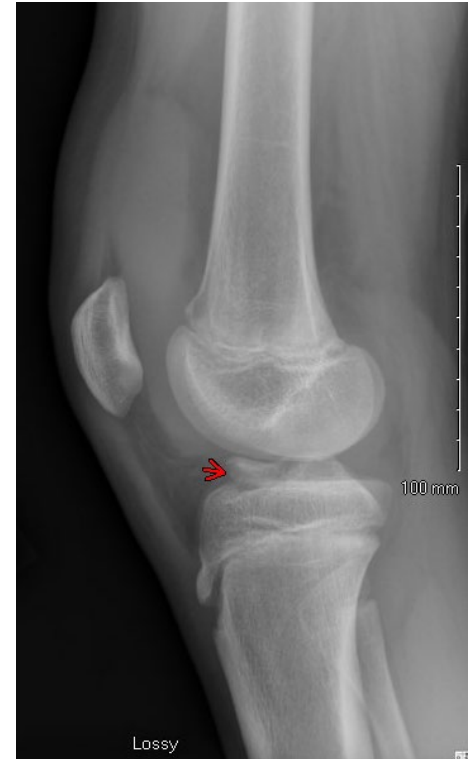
Xray of Type II tibial spine avulsion fracture
